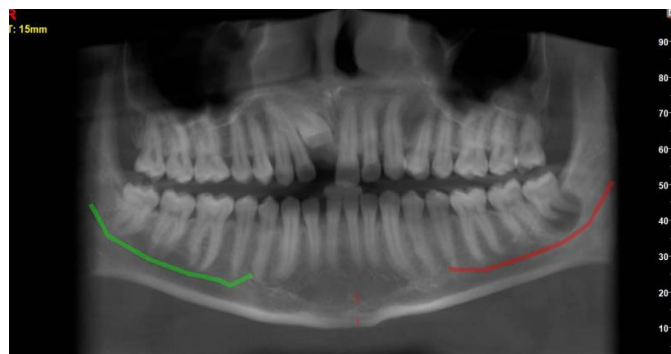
(showing unilocular radiolucency periapically with 38)
